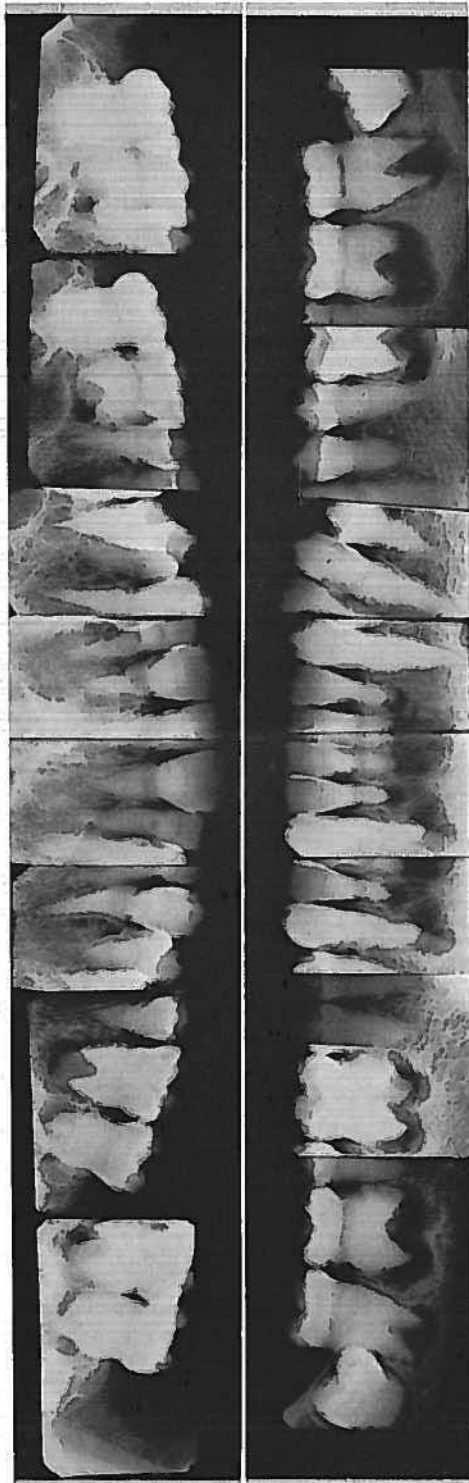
Roentgenograms of 18-year-old son showing irregular root formation with multiple periapical roentgenolucencies.
